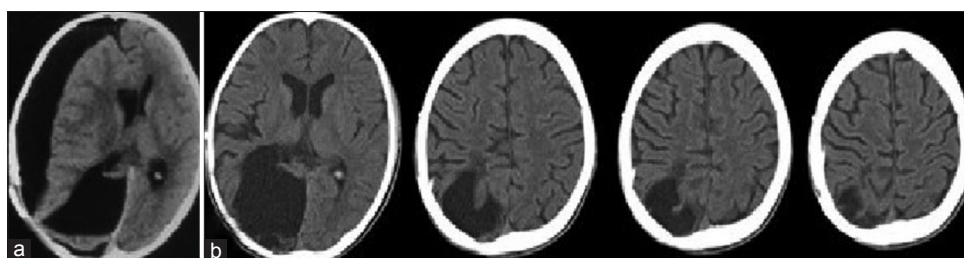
(a) Cranial CT showing the subdural hygroma. (b) Postoperative CT determined regression of subdural hygroma with flask, relaxed space, filled with cerebrospinal fluid
